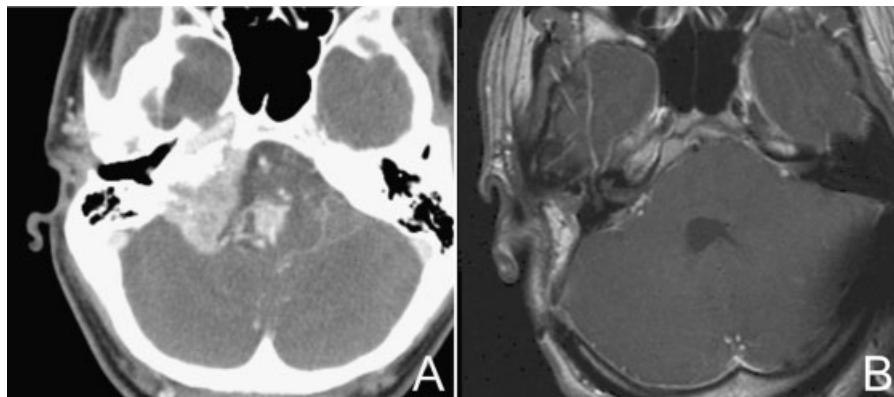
(A) Axial computed tomography images demonstrating a (4.8 cm maximum diameter) right-sided skull base lesion with significant intracranial growth. (B) One year postoperative axial T1-weighted magnetic resonance imaging with gadolinium enhancement demonstrating gross total tumor resection.
